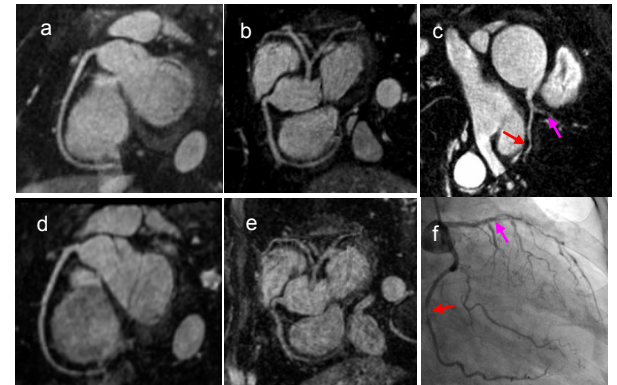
Coronary images with Radial EPI (a, b) and Cartesian EPI (d, e). Patient image using Radial EPI (c) and the corresponding X-ray angiogram (f).
